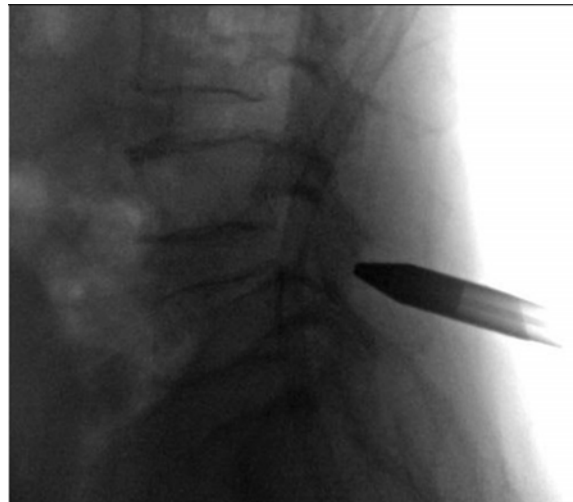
Lateral view x-ray shows depth of dilator at the level of facet joint.
